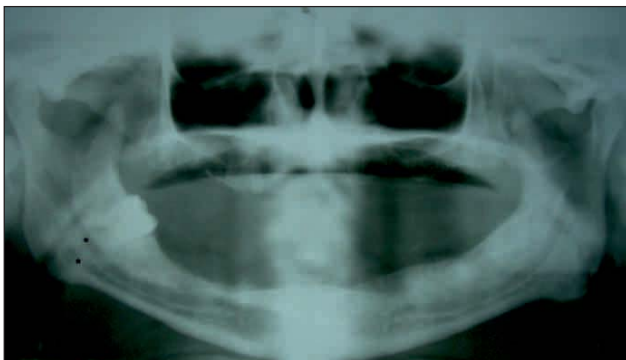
Orthopantomograph showing bifid mandibular canal (asterix)
